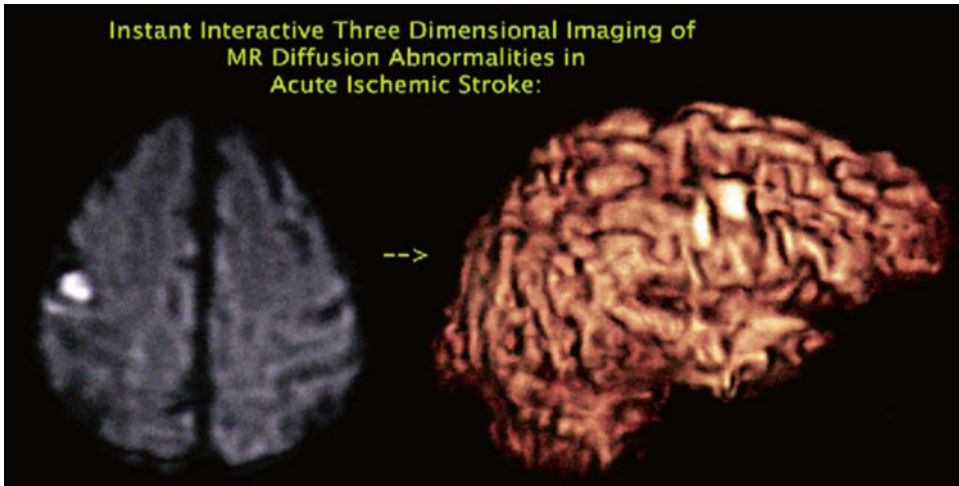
Diffusion-weighted MRI is a very sensitive tool in identifying acutely ischemic brain tissue
